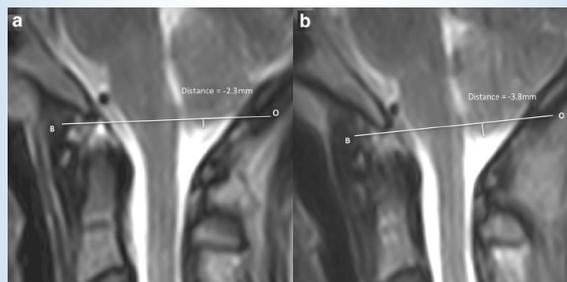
Sagittal T2-weighted MRI of the cervico-occipital junction of an AIS subject. The tonsil is lowest at the paramedian region. The tip of cerebellar tonsil is below (2.3 mm) the BO line (drawn on the midline) in supine position. b Sagittal image of same patient as Fig. 5a, in an upright position at the paramedian region. The tip of cerebellar tonsil descends more than in the supine position.
